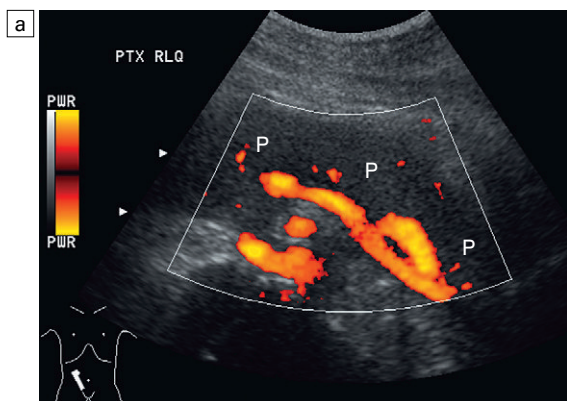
Power Doppler image of the transplant pancreas (P). (a) The vascular pedicle to the transplant pancreas is a prominent feature that helps to distinguish it from the surrounding bowel loops. (b) Setting scan parameters for slower velocities can depict branch vasculature within the pancreas transplant. This of course may be difficult when there is significant peristalsis in adjacent small bowel loops. (c) If a sufficient sonographic window is available, then a three-dimensional rendering of the vascular pedicle (arrow) can document its integrity.
